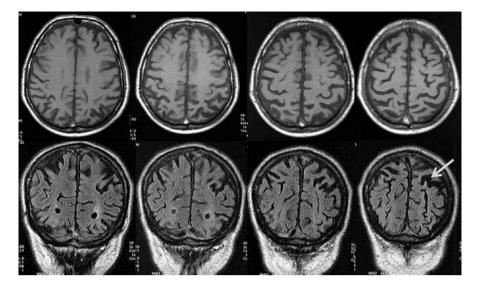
T1-weighted MRI scan (*upper line* axial angulation, *left* is caudal, *right* is dorsal; *lower line* coronal angulation, *left* is rostral, *right* is occipital). Note the widening of sulci, especially on the right side (*white arrow*) (MRI scan with friendly permission from Prof. Dr. C. Will, Bocholt)
